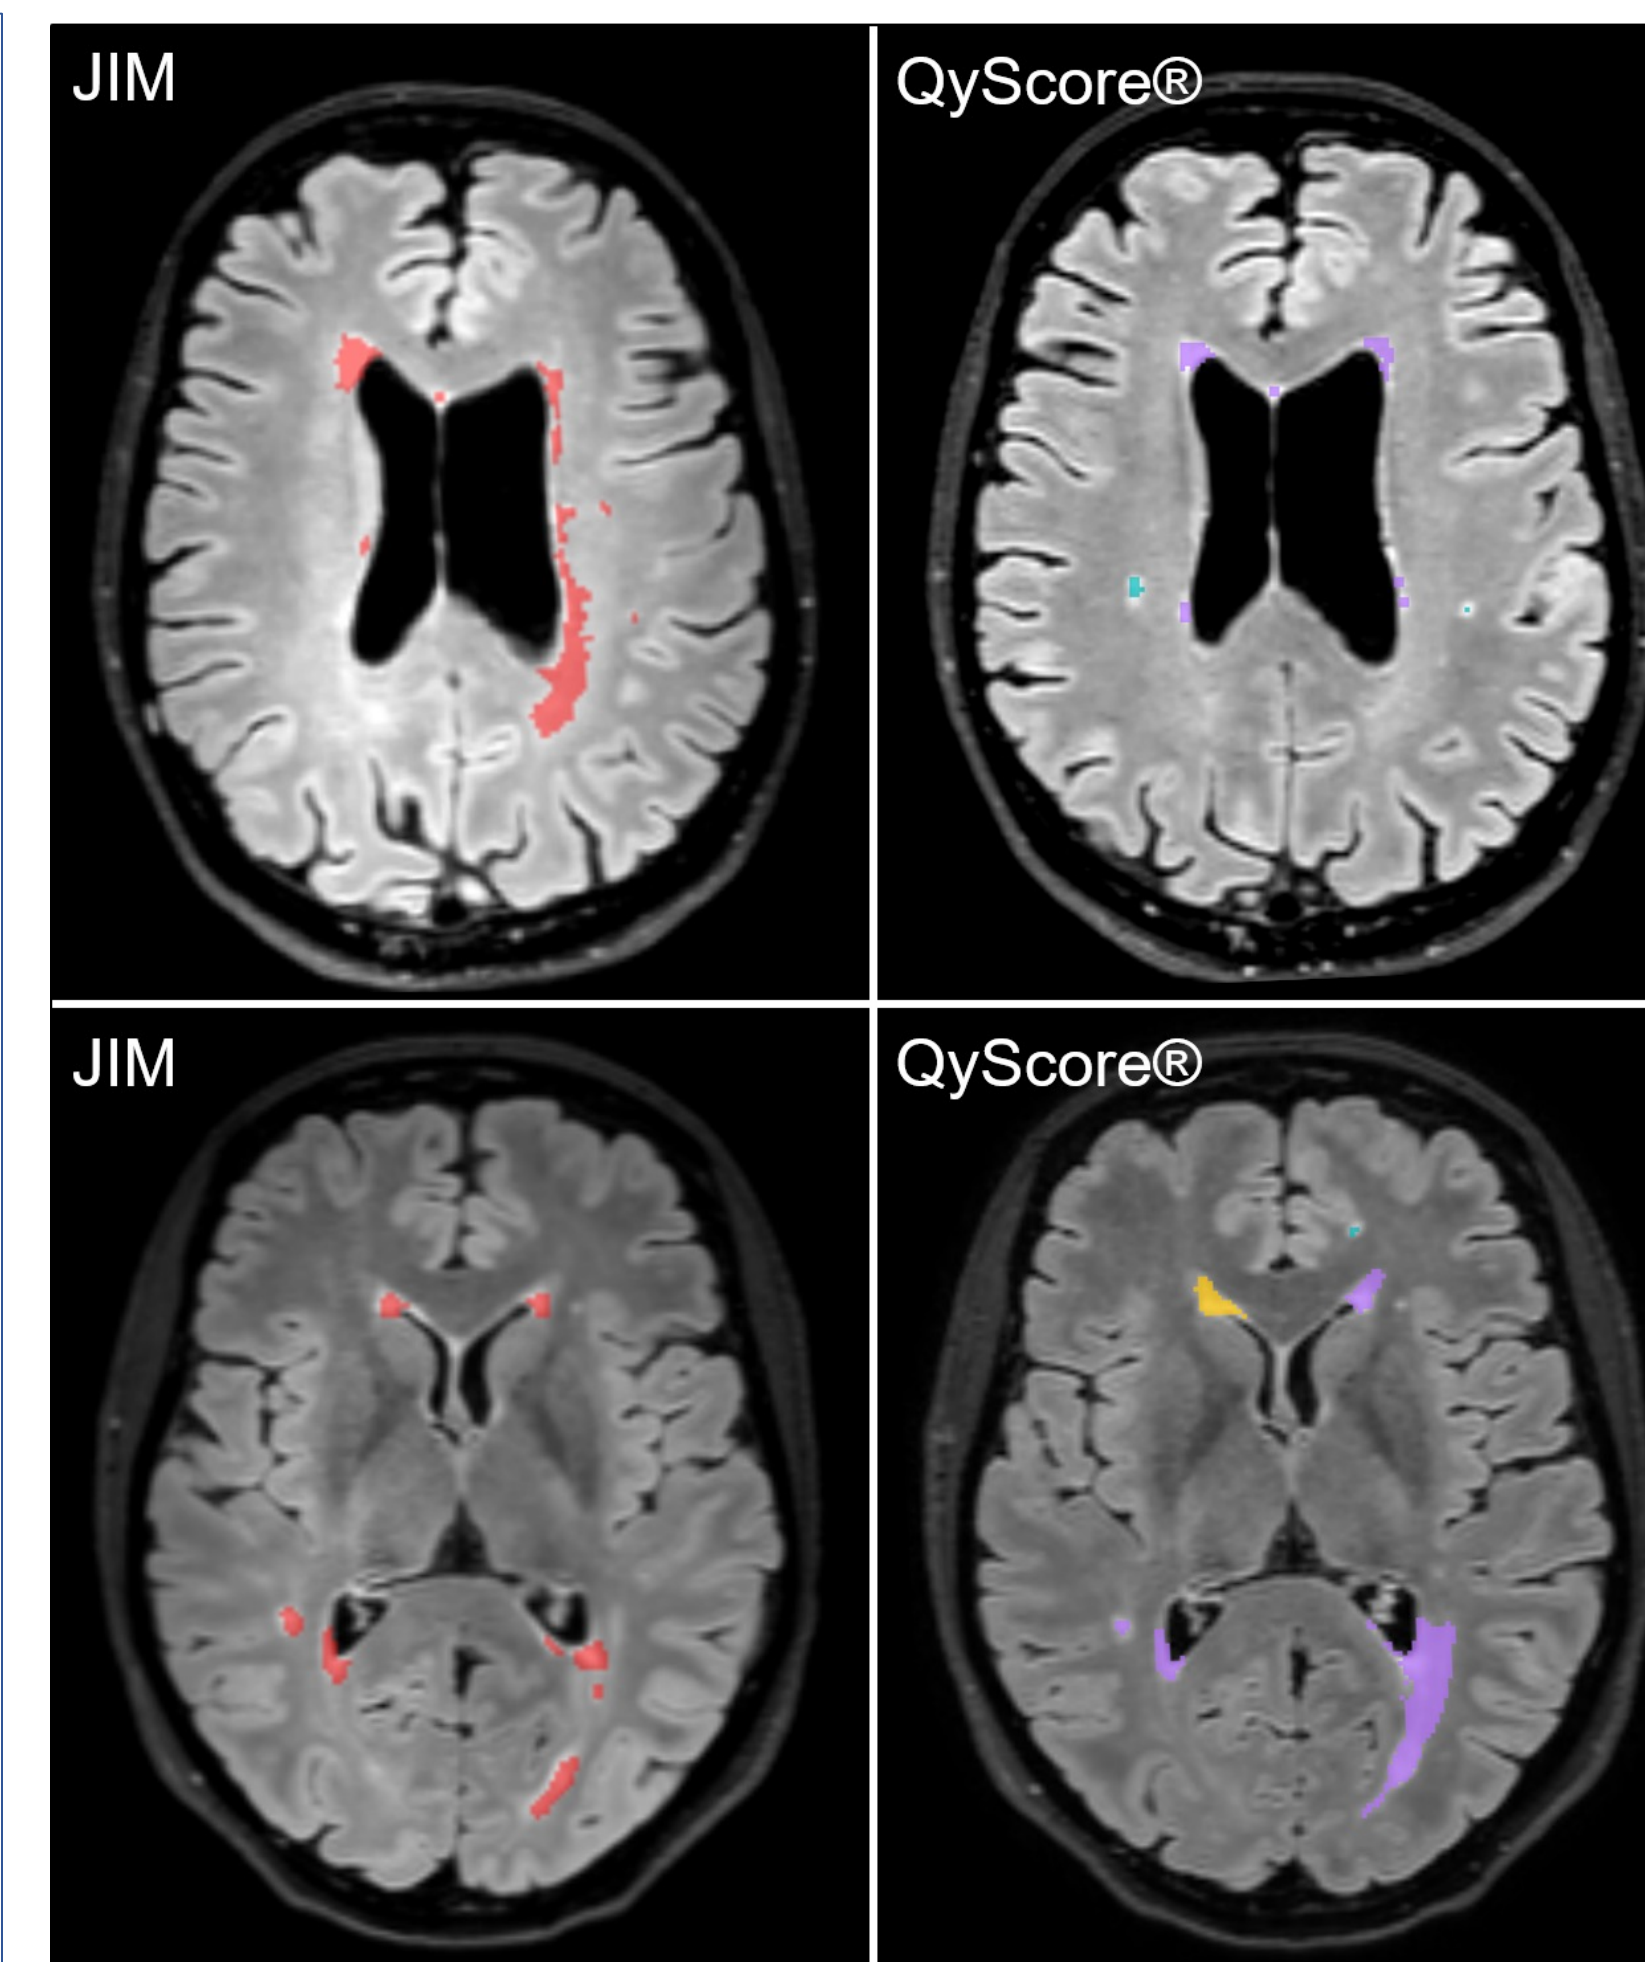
Comparison between MS lesions in T2W FLAIR by JIM and QyScore®
